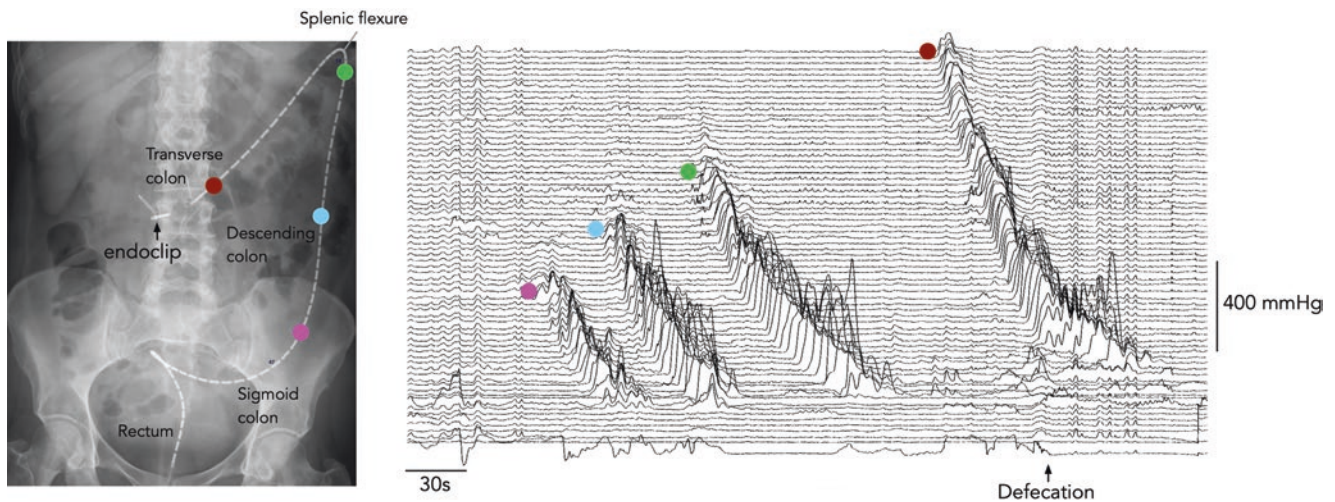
Abdominal radiograph showing a fiber-optic manometric catheter placed in the colon with the tip located in the mid-transverse colon. To the right of the X-ray is a manometric trace showing an array of high amplitude propagating contractions (HAPC) in the build up to defecation. The colored circles on the X-ray image correspond to the location of the start of each of the HAPC. The first HAPC (pink circle)
